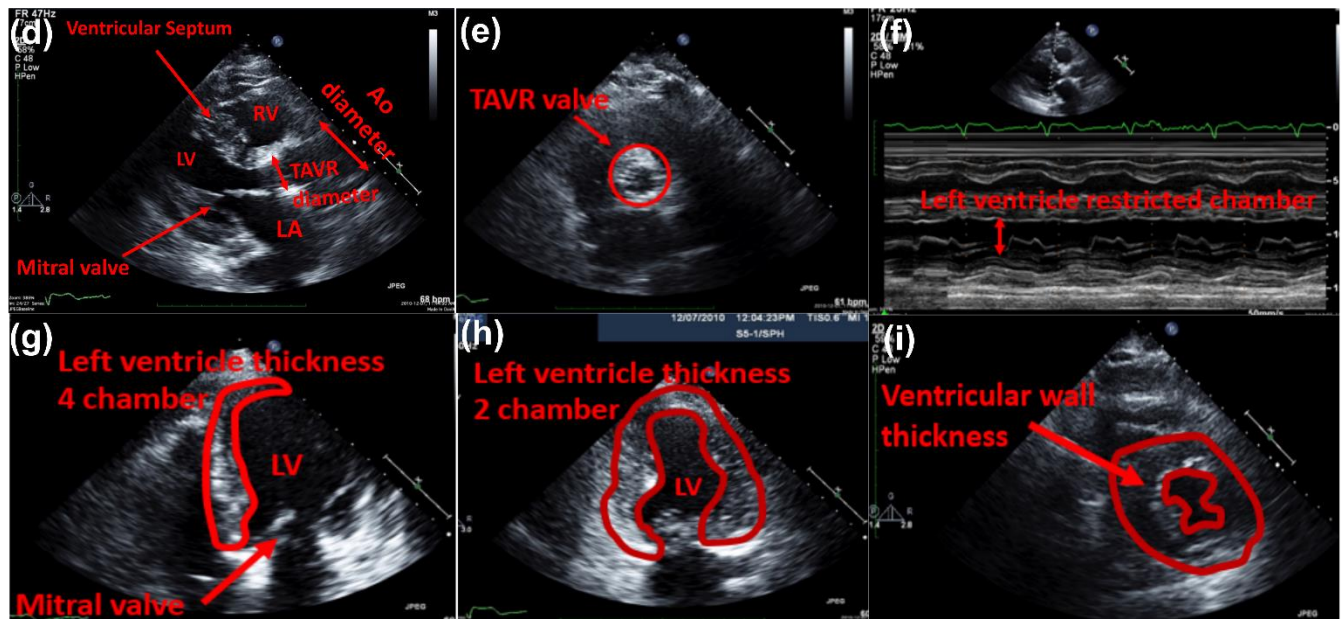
Hemodynamics parameter: (a) mitral inflow velocity ($E/A = 0.6$), showing grade I diastolic dysfunction, impaired relaxation); (b) 4 chamber view and color doppler echo of the LV during diastolic phase; (c) 4 chamber view and color doppler echo of the mitral valve during diastolic phase. Geometrical parameters: (d) Parasternal long-axis view associated with different parts of the LV; (e) Parasternal short-axis view of TAVR. (f) M-Mode measurement showing restricted LV chamber; (g) Apical 4 chamber view showing LV thickness and mitral valve dimensions; (h) Apical 2 chamber view showing LV thickness; (i) Parasternal short-axis view of the LV tissue showing the hypertrophic cardiomyopathy as well as the restricted chamber.
